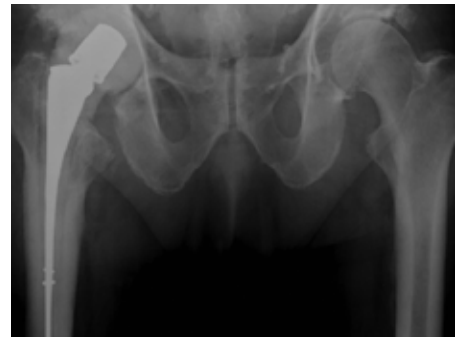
Preoperative AP radiograph of pelvis prior to reimplantation surgery. This radiograph was taken 8 weeks after resection arthroplasty. All Calcium Sulfate beads have dissolved. Preoperative aspiration of the hip was negative.
